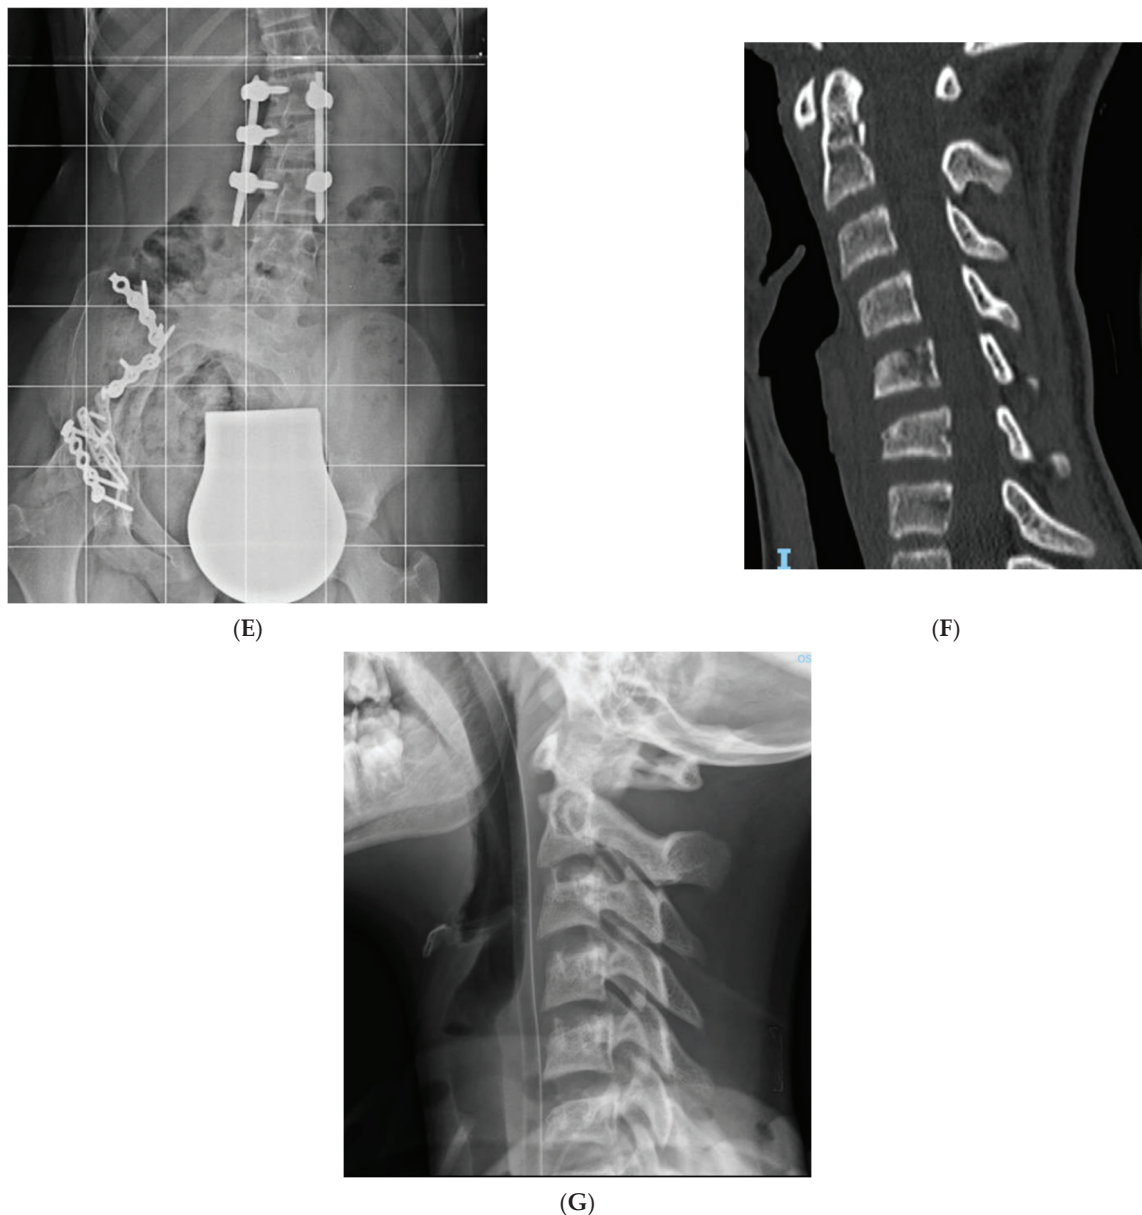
Case 6 (Table 1): (A,B) preoperative axial CT scan of L1 and L2; (C) preoperative sagittal CT scan of lumbar spine; (D,E) anteroposterior and lateral X-ray of lumbar spine after surgery; (F) sagittal CT scan of post-traumatic cervical spine; (G) X-ray lateral view in Halo-Vest.
